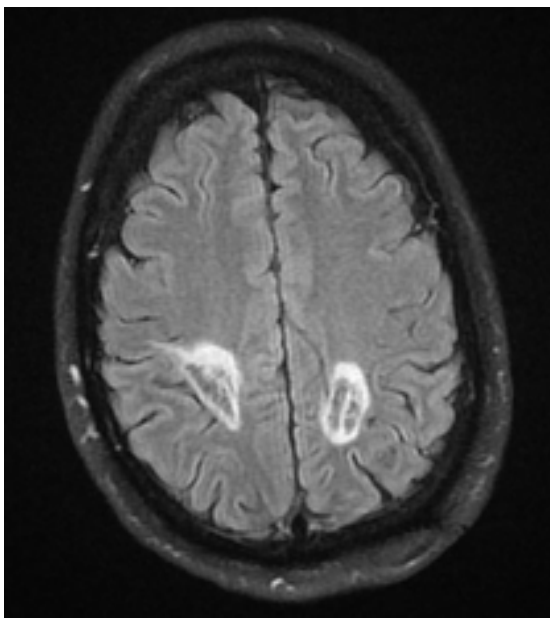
MRI images in T2 Flair sequence taken three months post treatment showing a decrease in size in both parietal lobe lesions
